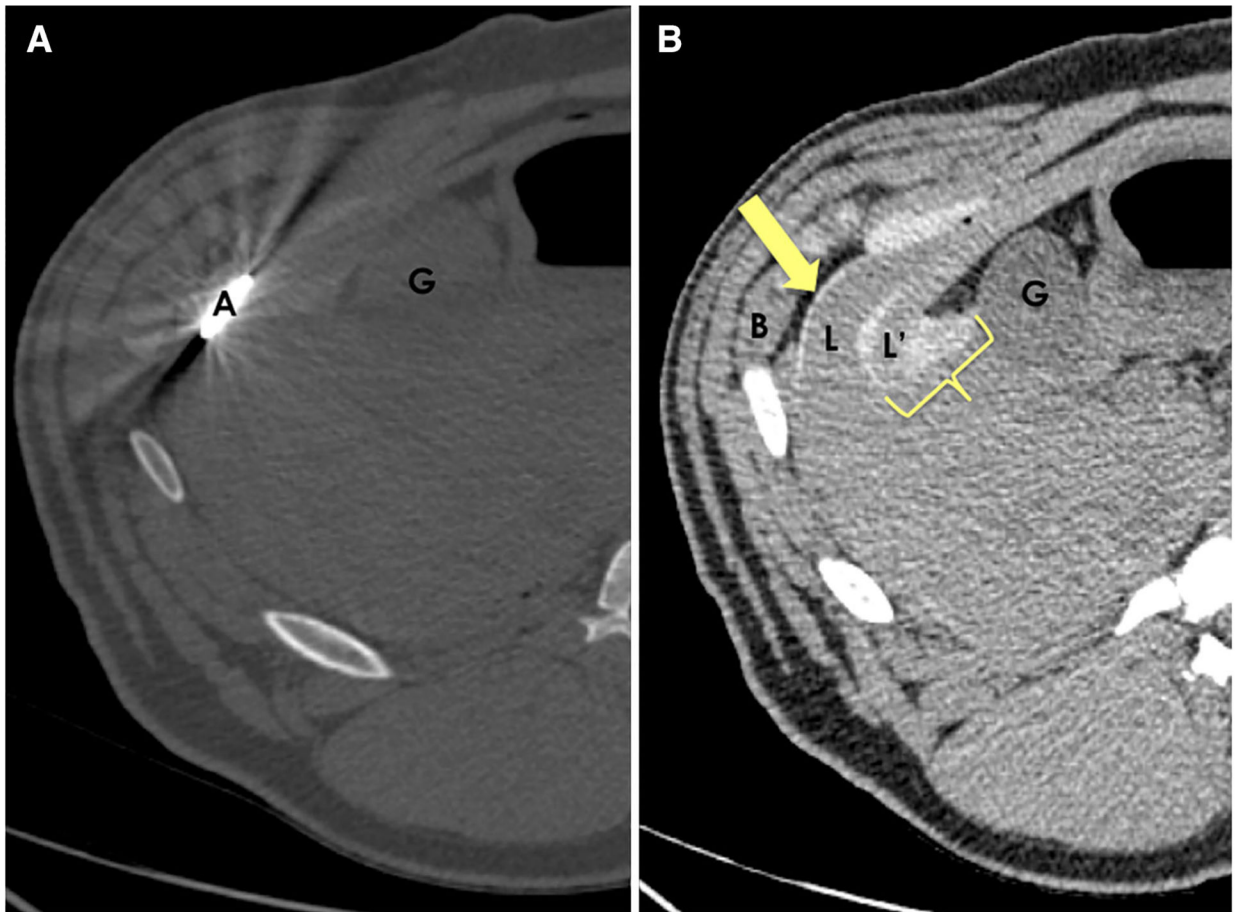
P407 placement within a complex space to protect multiple non-target tissues simultaneously. (A) MW antenna placement and (B) slightly inferior axial CT slice with less streak artifact to better depict anatomy. Antenna (A) was placed within the target tissue: in this case, the most lateral portion of the liver (L). Body wall (B), another lobe of the liver (L'), and the gallbladder (G) were all in close proximity to the desired ablation site. Percutaneous injection of P407 allowed for formation of a gel barrier between the target liver lobe and the body wall (*arrow*), as well as a barrier enveloping the second liver lobe and abutting the gallbladder (*bracket*)
